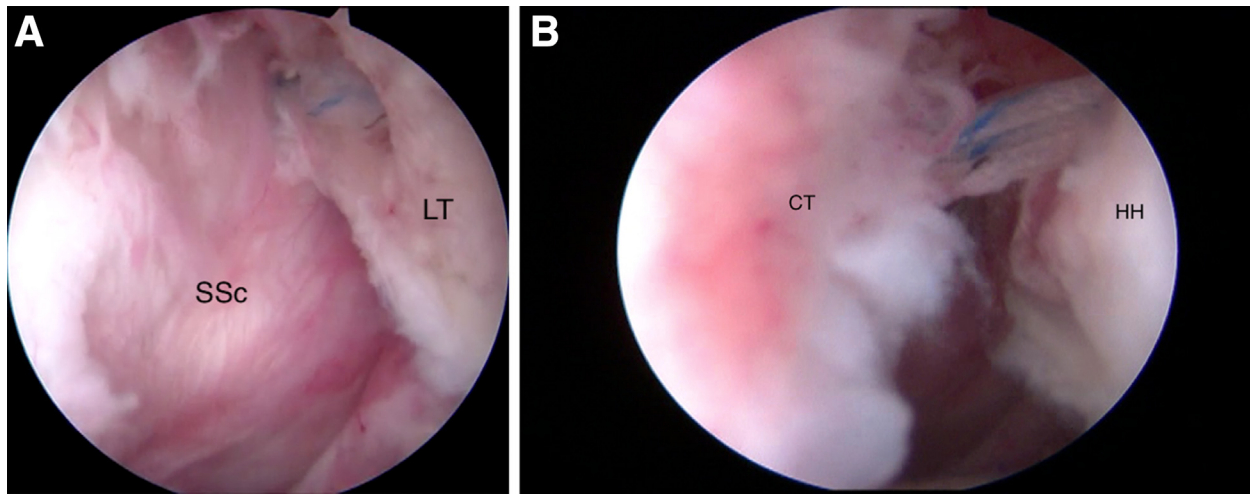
Two double-loaded Q-FIX (Smith & Nephew, Memphis, TN) suture anchors are placed in the lesser tuberosity through subscapularis via the anteroinferior (5 o'clock) portal. A view from the anterosuperior portal on the right shoulder. (A) inferior anchor. (B) Superior anchor. CT, capsular tissue; HH, humeral head; LT, lesser tuberosity; SSc, subscapularis tendon.
